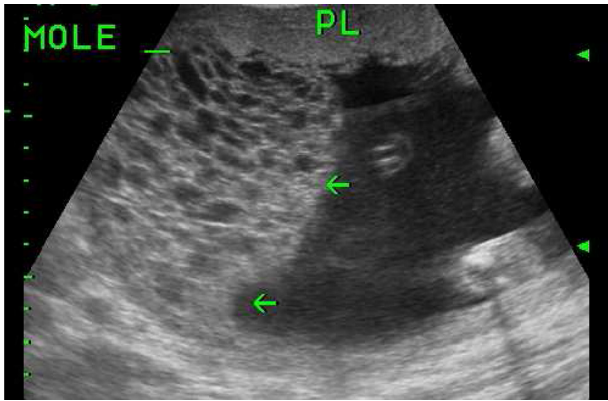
Ultrasound scan at 20 weeks of gestation showing a live fetus and one hydatidiform mole (arrows) located at the uterine fundus with a grape-like appearance. PL = normal placenta.
